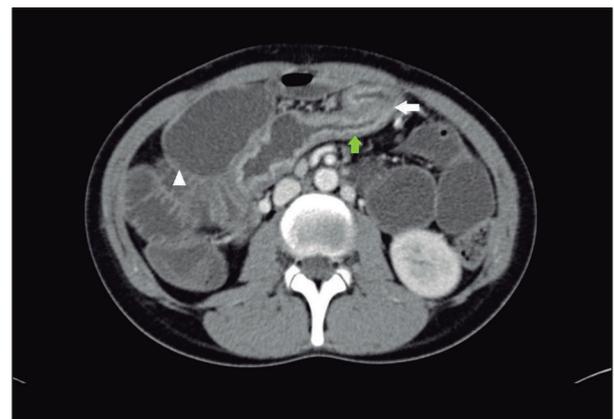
Axial image of CT enterography. Marked wall thickening and mucosal hyper-enhancement in a portion of the medium ileum (green arrow) with an area of stenosis (white arrow) and dilatation of the small bowel (arrowhead).
